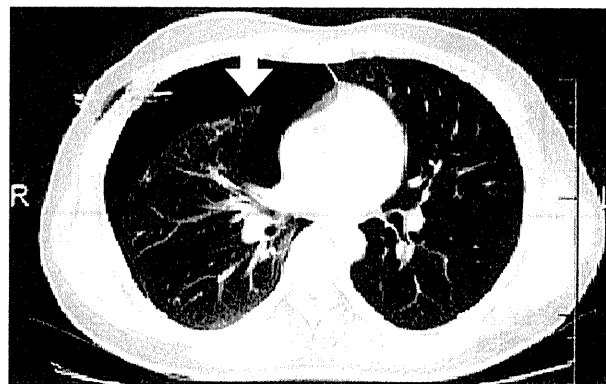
発症後 5 日目単純 CT. 右上葉に隔壁構造を有する腫瘤を胸膜下に認め (矢印), 発症原因と考えられた。
